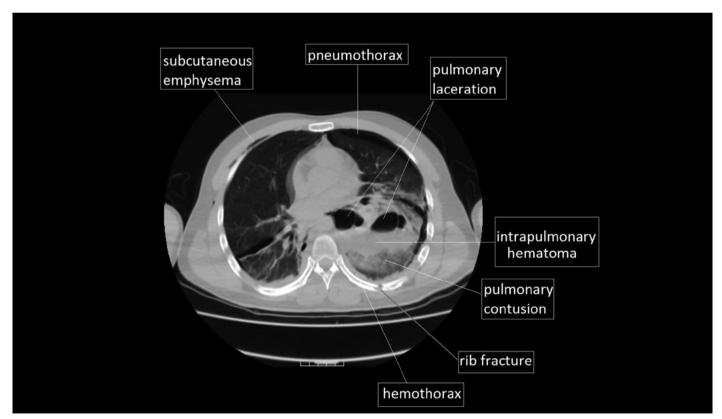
Various types of thoracic trauma seen on thoracic computed tomography
